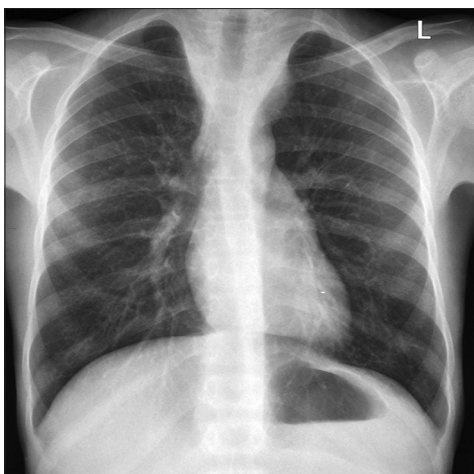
Chest radiograph showing mediastinal widening in the superior part
